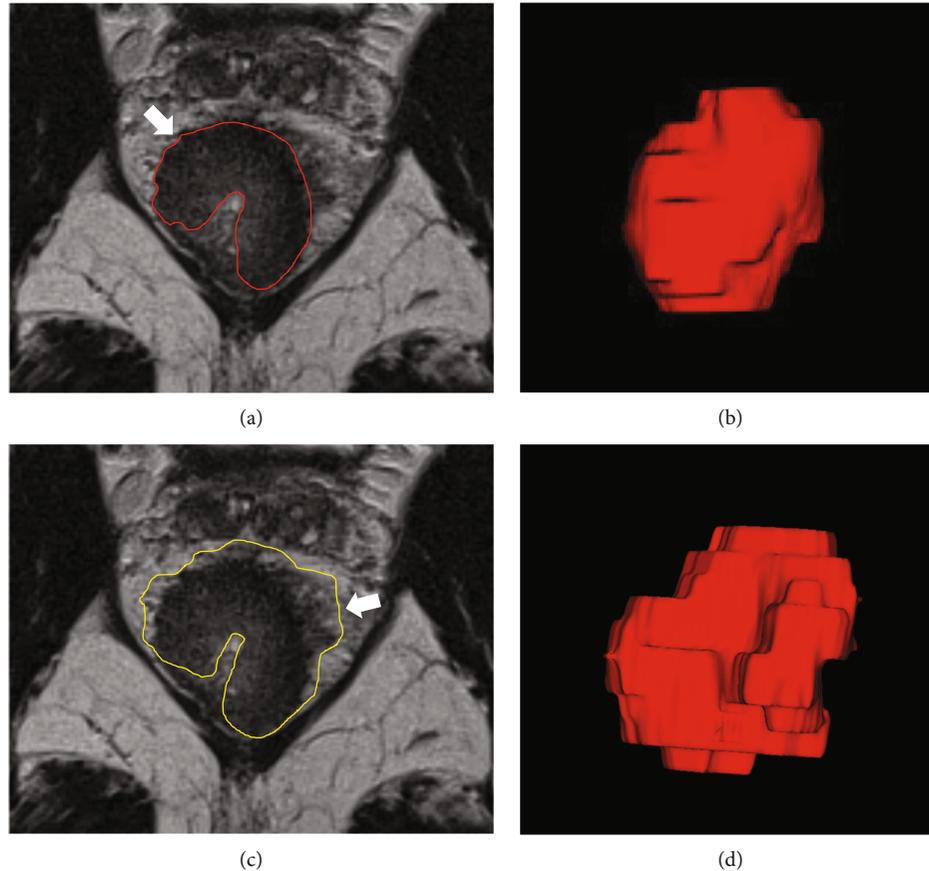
Representative images for lesion delineation. (a, b) Minimum delineation of ROI on oblique-axial T2-weighted MR images (arrow) and volume renderings of VOIs (Method 1). (c, d) Maximum delineation of ROI on oblique-axial T2-weighted MR images (arrow) and volume renderings of VOIs (Method 2).
